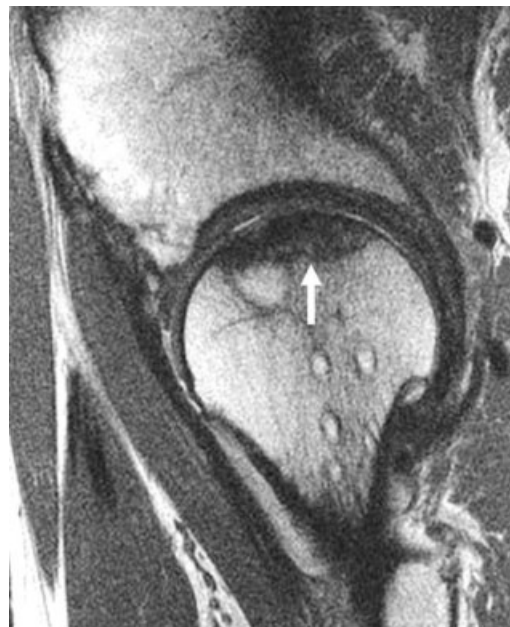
Sagittal proton density MR image of a 52-year-old man with osteonecrosis demonstrates marked low signal intensity marrow (arrow) that remained low signal in STIR images, indicative of devitalized marrow. The patient went on to subsequent collapse and arthroplasty.
